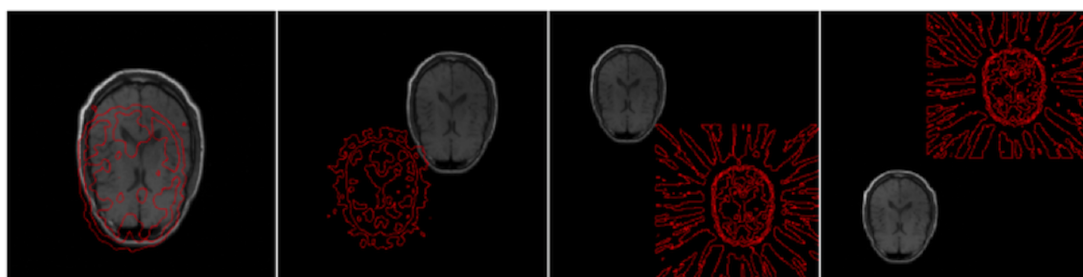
CT-MR in-plane translational misalignments. An axial plane view of a PET contour plot overlaid onto its T1 pair is shown. From left to right, overall misalignment (Euclidean distance of applied misalignment in each dimension) was: 37.94, 186.6, 329.2 and 359.2 mm. PET background noise is enhanced in the two most misaligned cases (on the right) to clearly define volume limits.
